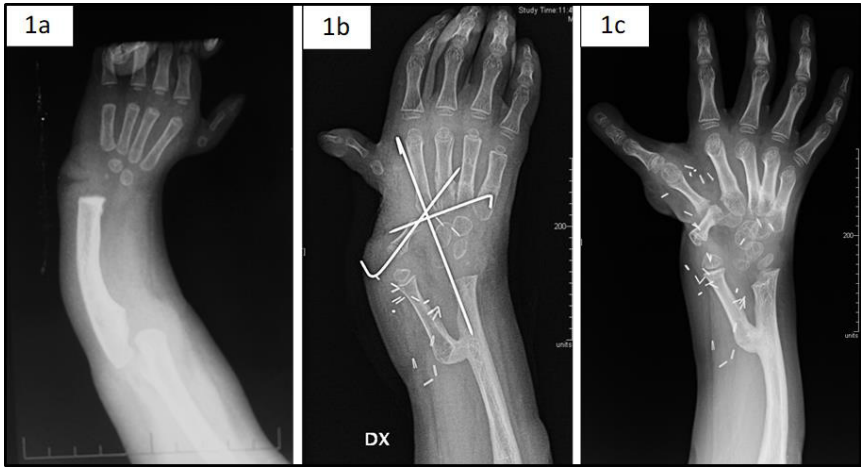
Patient 16 radiographs
